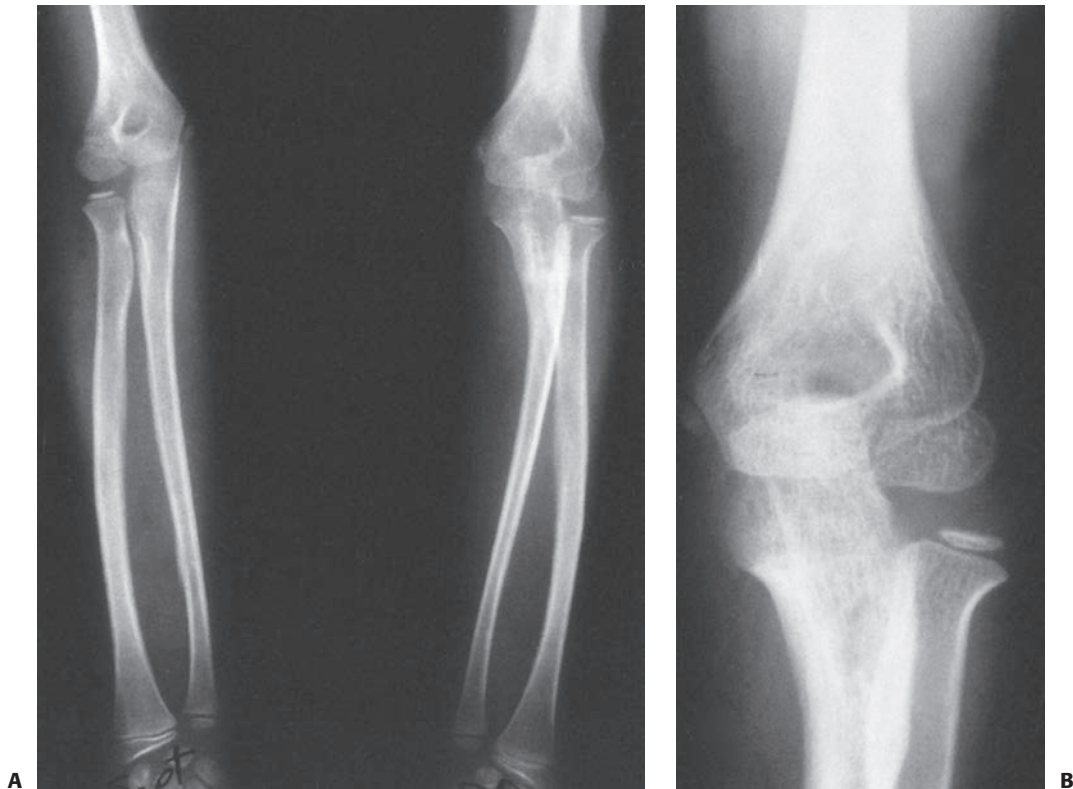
Type III lesion. A: AP radiographs of the bilateral forearms demonstrate residual bow of the proximal ulna after an incompletely reduced type III lesion (persistent varus deformity). B: The persistent bow resulted in symptomatic lateral subluxation of the radial head.
